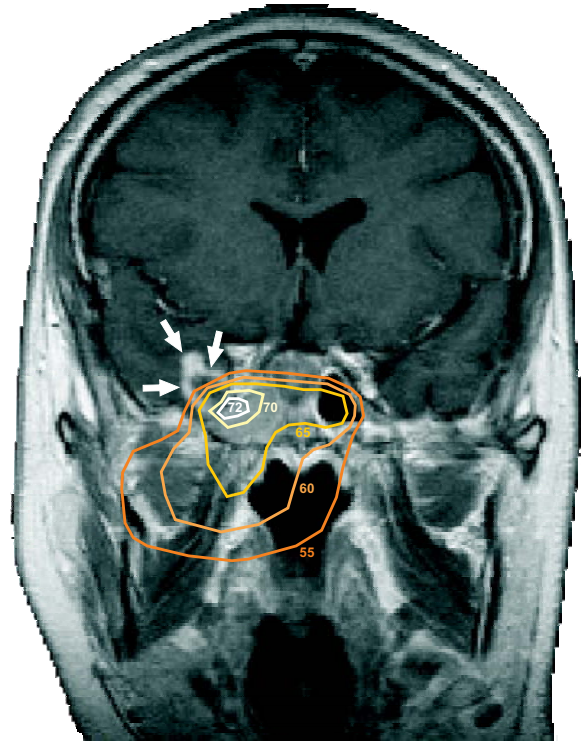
Coronal view of a magnetic resonance image (MRI) showing the zone of brain necrosis (white arrows) in patient 1 from Table 5. The MRI was acquired two years after the end of radiotherapy. The planning CT was matched to the MRI, and the dose distributions were transferred to the MRI. All iso-doses are in Gy.
